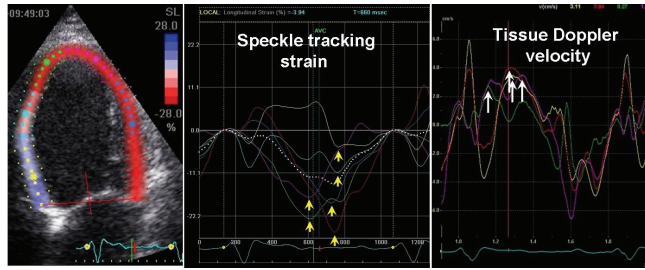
Representative traces from a 4 chamber view in a patient with left bundle branch block. Left panel: traces showing peak strain by speckle tracking echocardiography (yellow arrows). Right panel: traces showing peak ejection velocity (white arrows) by tissue Doppler velocity.
